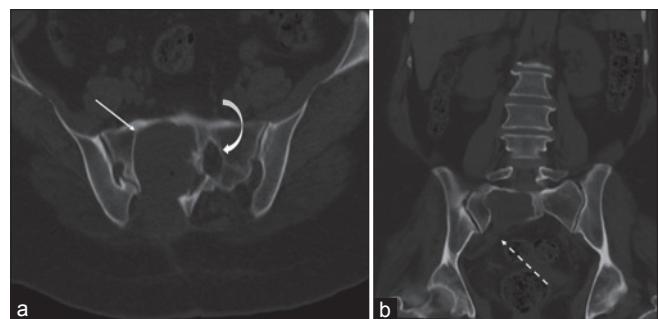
Computed tomography scan of pelvis, (a) axial and (b) coronal views reveal gross widening of right S1 neural foramina (arrow) showing thin sclerotic margins with an associated large soft tissue lesion completely filling it and extending into the pelvis along the dehiscent postero-inferior walls (dashed arrow). Note is made of the normal sized left S1 neural foramina (curved arrow).
